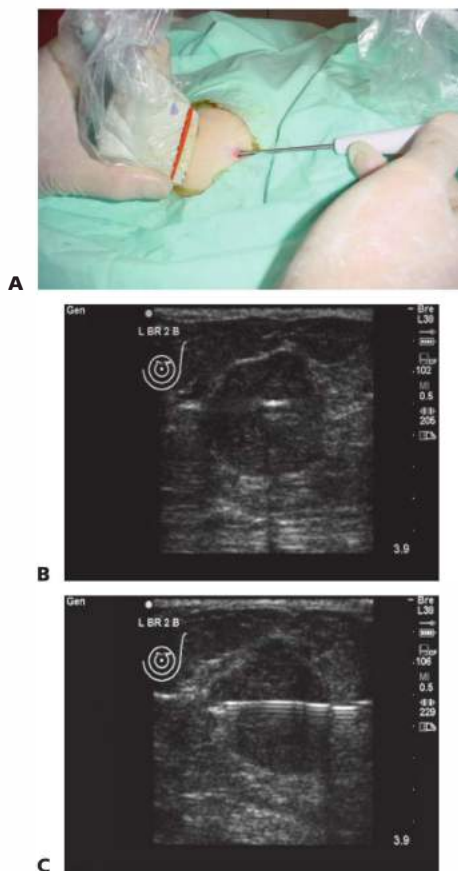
• A. Ultrasound examination of probe placement to confirm central location within fibroadenoma. B. Ultrasound view of probe in tumor via transverse image. C. Ultrasound view of probe in tumor via longitudinal image.
